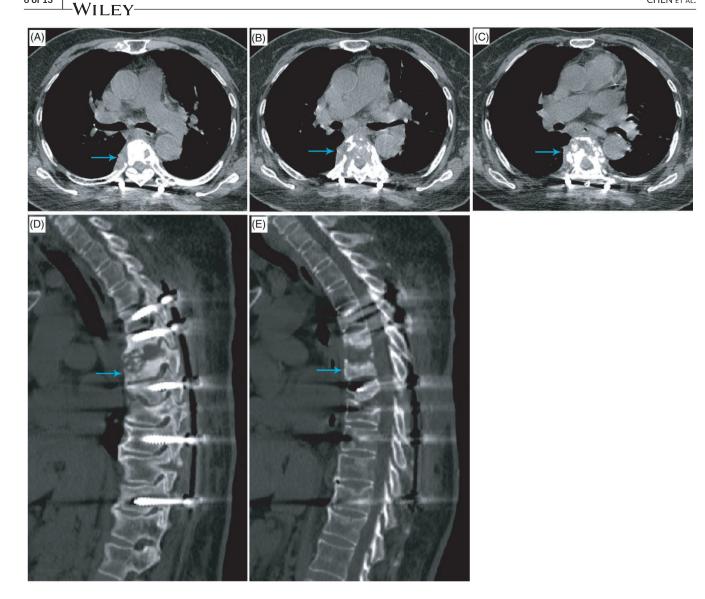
Preoperative CT examination performed during the third surgery. (A) The arrow points to the T5 paraspinal abscess. (B) The arrow points to the T5/6 paraspinal abscess. (C) The arrow points to the T6 paraspinal abscess. (D and E) The arrow points to the bone destruction in the T6 vertebral body
